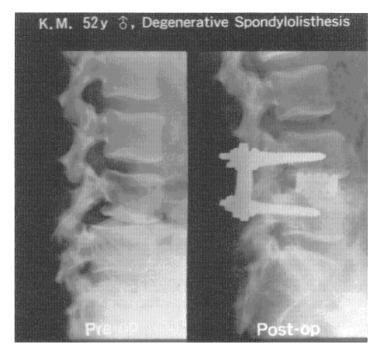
Radiograph showing A/W glass-ceramic used to treat lumbar instability.
